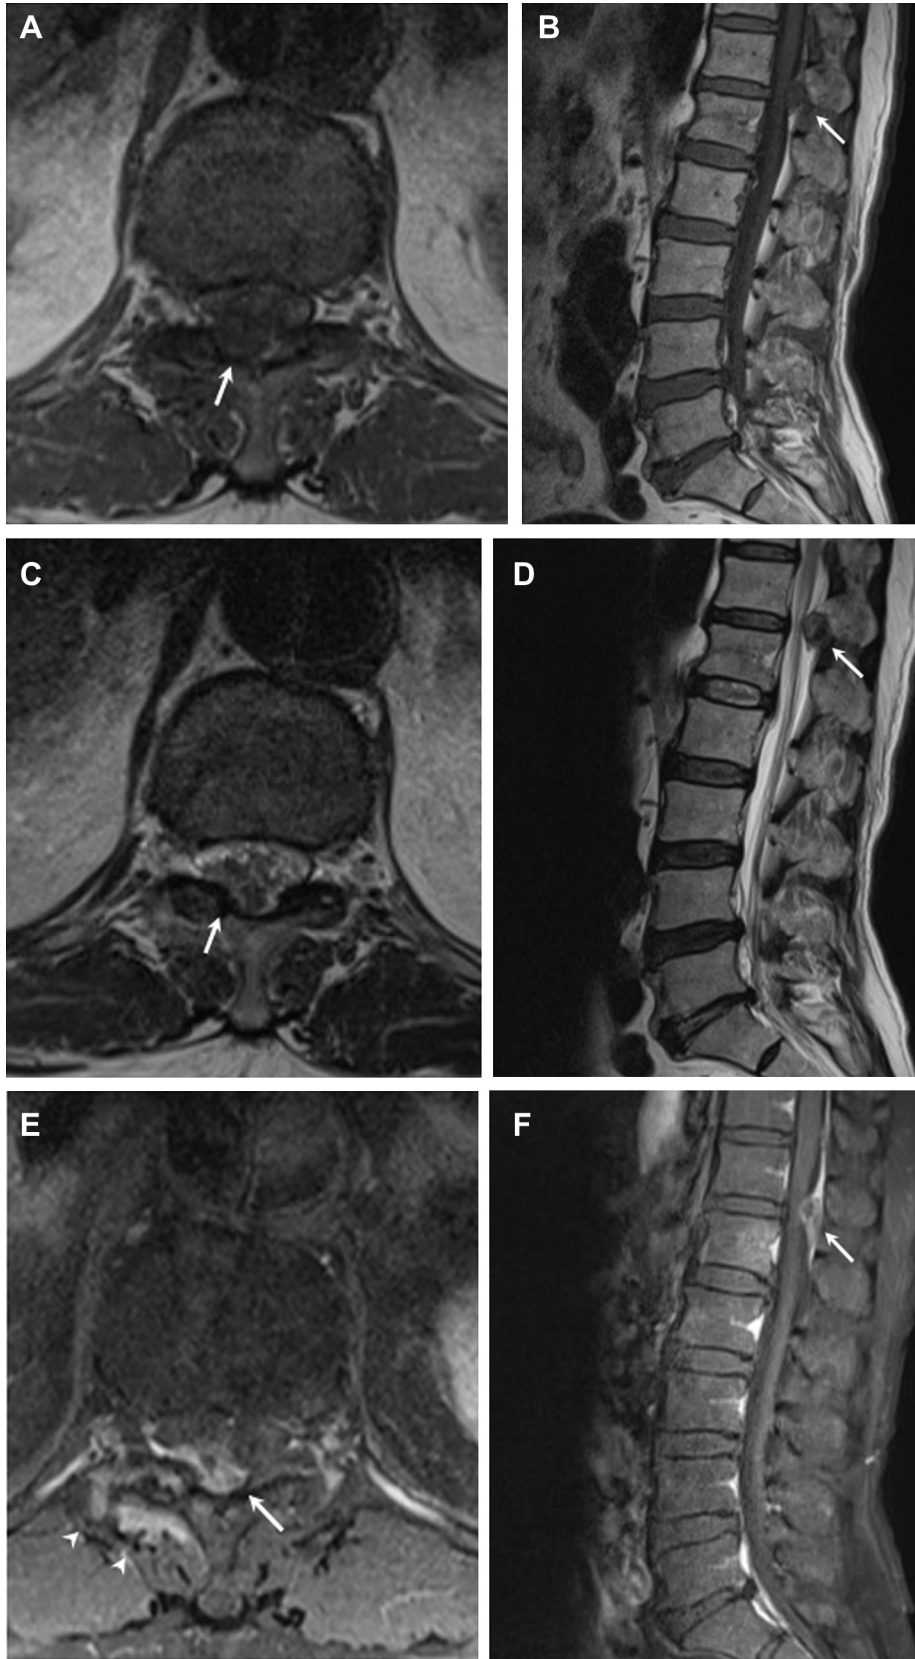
(A, B) T1-weighted images show an isointense epidural nodule (arrow) with cord compression. (C, D) T2-weighted images show a hypointense epidural nodule. (E, F) T1-weighted images with gadolinium enhancement show rim enhancement of the nodule (arrow) and enhancement of some paraspinal soft tissues (arrowheads).
